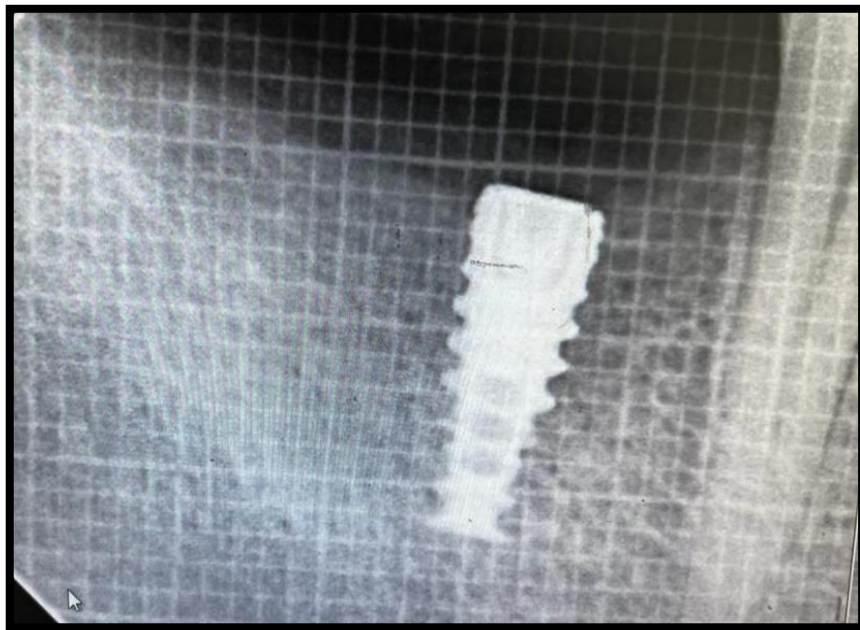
Post -op radiograph
